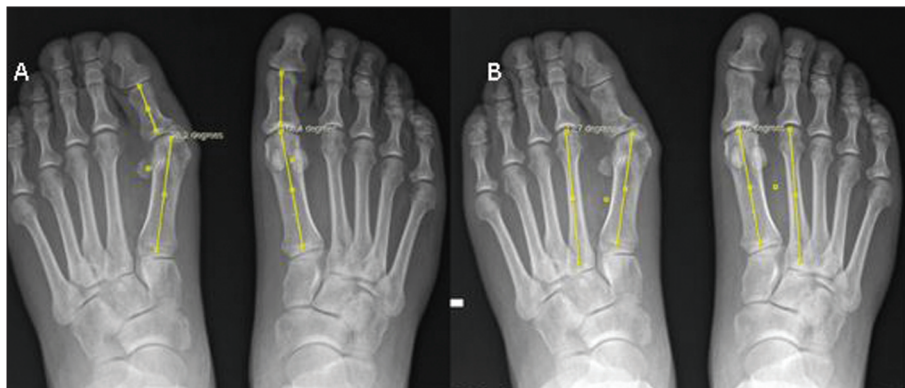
A) Bilateral standing antero-posterior (AP) radiographs showing the hallux valgus angle (HVA) measurements of each foot. B) Bilateral standing AP radiographs showing the intermetatarsal angle measurements of each foot.
